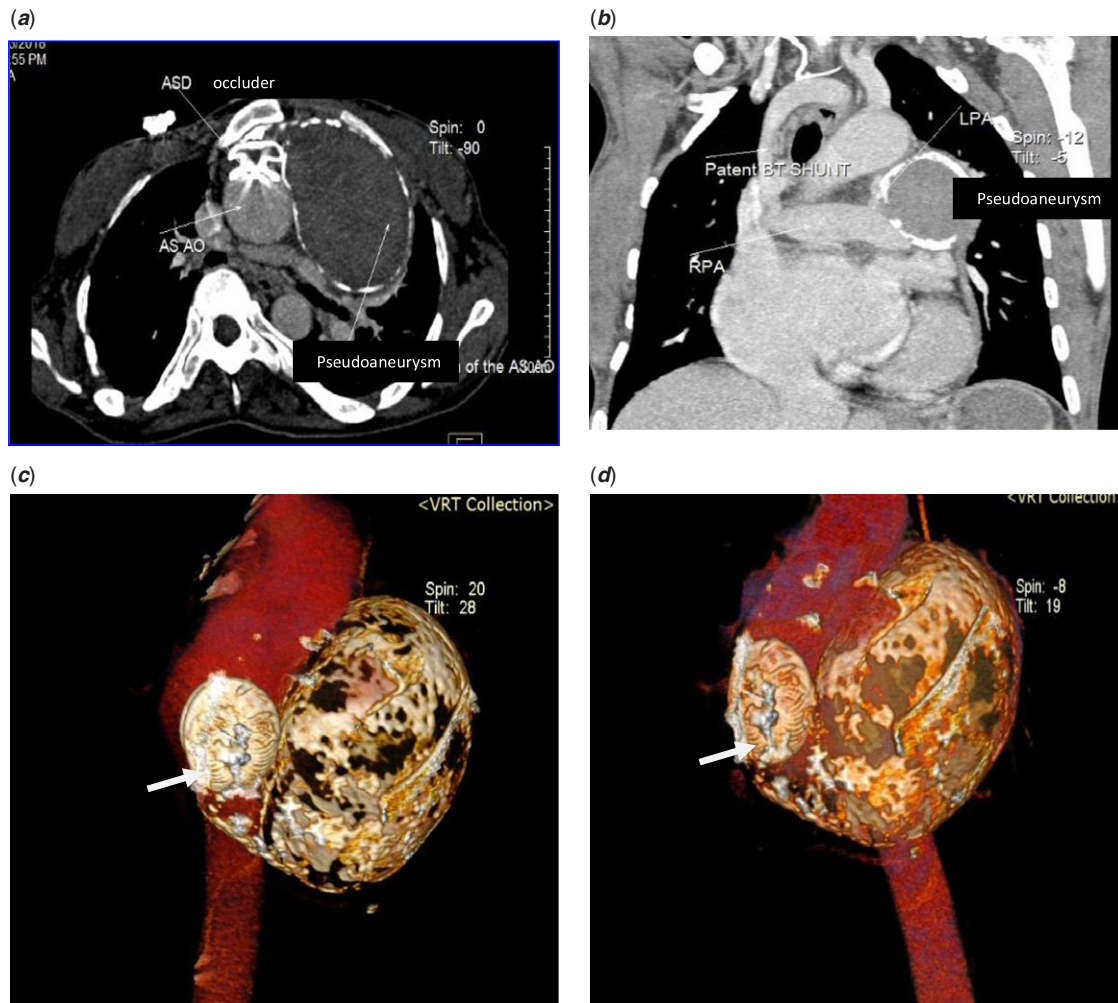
Post-operative tomography scan. (a) Axial view demonstrates exclusion of the ascending aortic pseudoaneurysm with an Atrial Septal Occluder (ASD occluder). (b) Patent venous graft (BT shunt) between the aorta and right pulmonary artery. (c and d) A volumetric three-dimensional CT images after device occlusion of pseudoaneurysm. Device was seen in situ (arrow).
